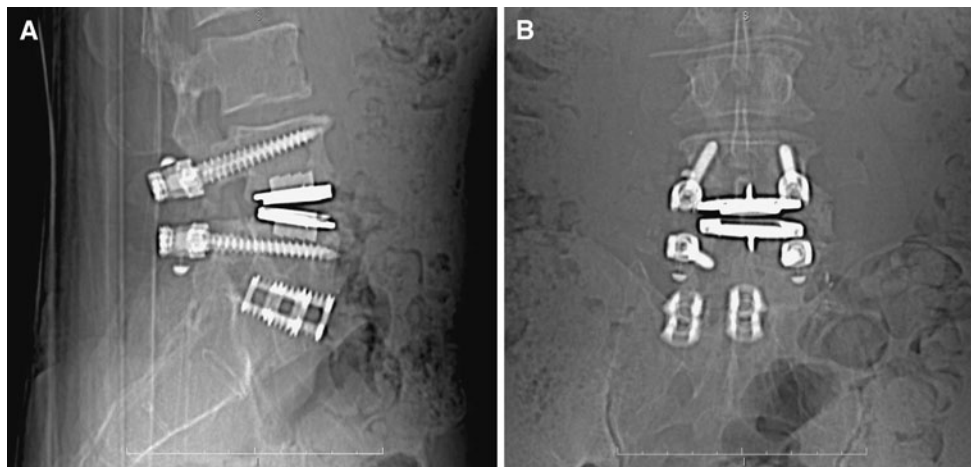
Pre-revision antero-posterior and lateral radiographs of a 45 year-old male patient, implanted with PEEK rods as a salvage procedure for hybrid stabilization using an artificial disc at L4–L5 (Case 9, Table 1). Revision took place 0.5 years after implantation due to nonunion
